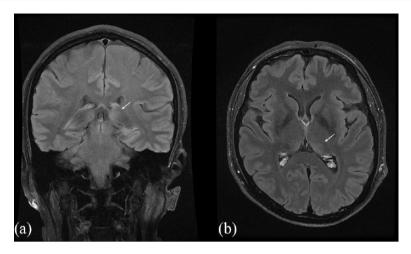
MRI fluid-attenuated inversion recovery (FLAIR) images: (a) coronal, August 2016; (b) axial, April 2017 with abnormal hyperintensity in the thalamus and pulvinar predominantly on the left.
